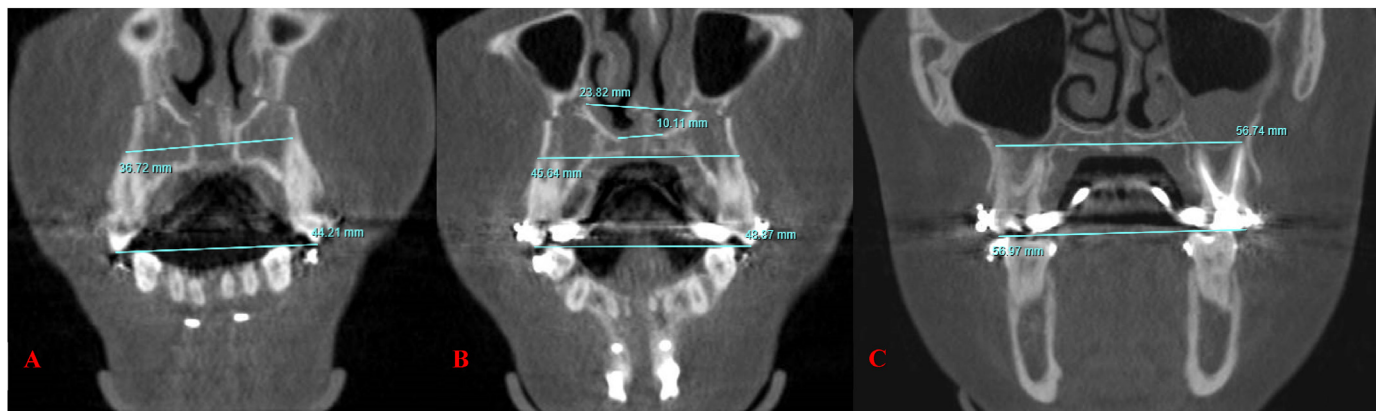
Dental and skeletal measurements regarding tooth-borne SARME using coronal CBCT slices at T1, T2 and T3. A: MAXICTD, MAXICAD; B: MAXIFPTD, MAXIFPAD, MAXPALW, MAXPABW; C: MAXIFMTD, MAXIFMAD.
